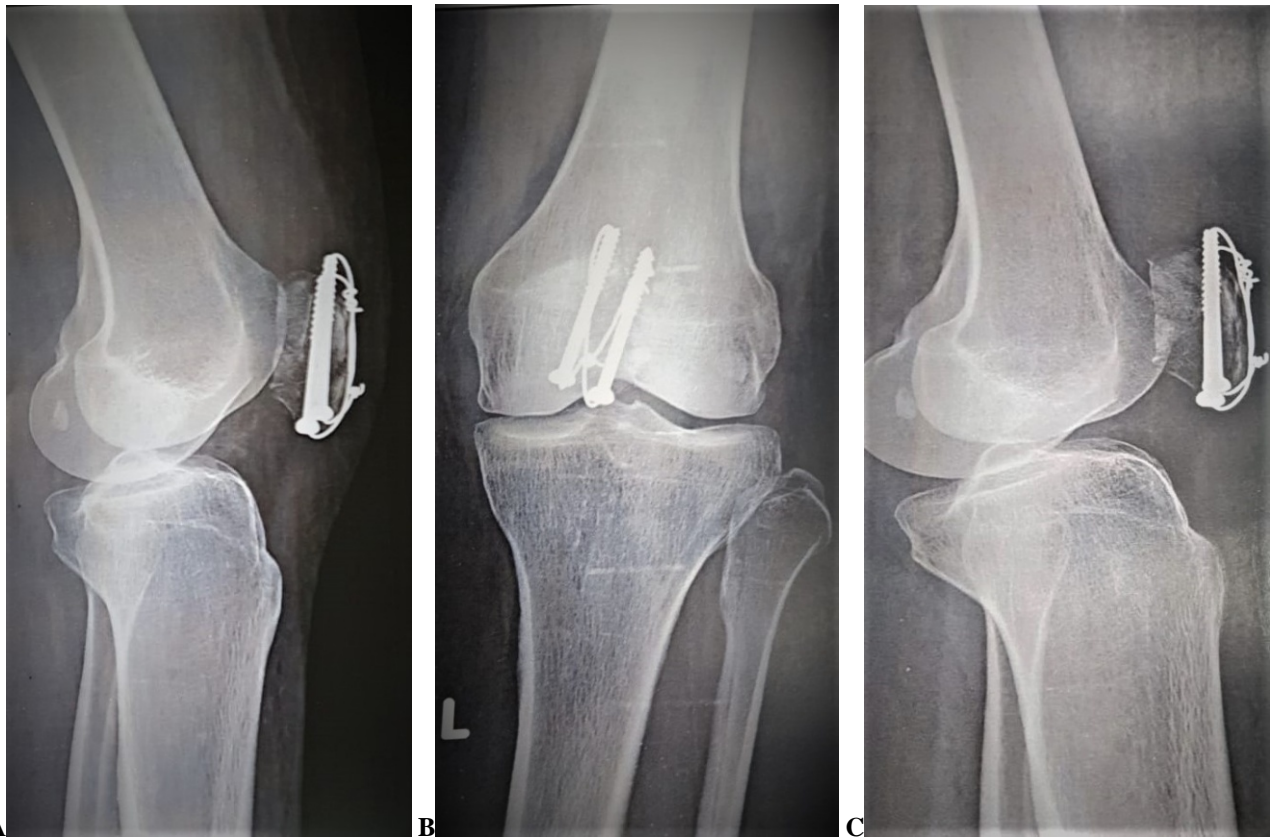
One-month postoperative lateral radiograph for a female patient 41 years old (case no. one), with a transverse fracture patella fixed with the technique described. B: One-month postoperative AP radiograph of case no. one. C: Six-month postoperative lateral radiograph of case no. one.
